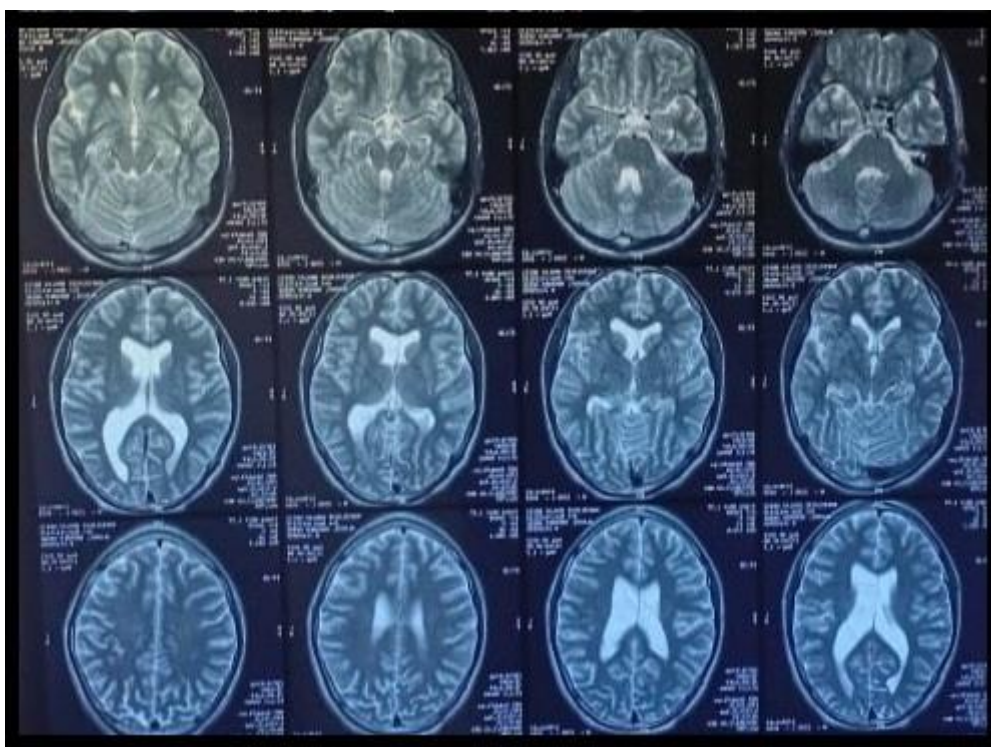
Magnetic resonance imaging of the brain showing T2 hyperintensity signals involving the posterior part of the globus pallidus
